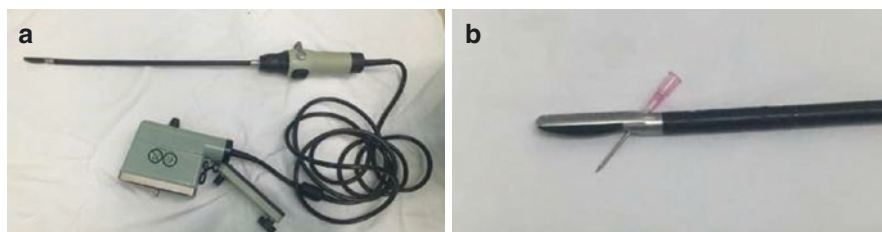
The laparoscopic ultrasound transducer. (a) the general view of the transducer; (b) the guiding tunnel of the transducer
